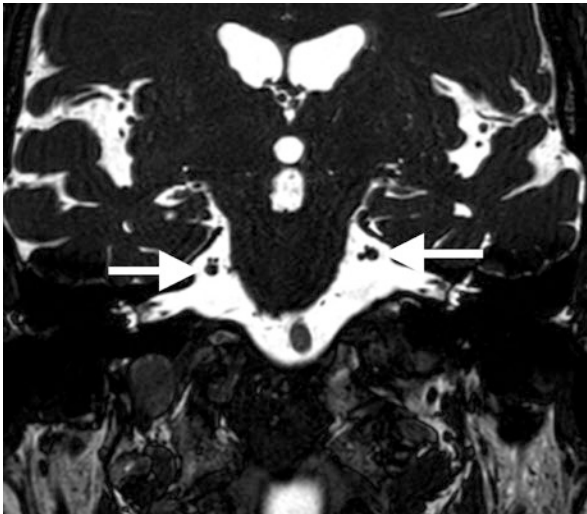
Coronal T2-weighted SSFP image depicts the cisternal segments of each trigeminal nerve (arrows). Both nerves are bordered by pairs of vessels (hypointense foci along the superior border of the right CN V and medial and superior-medial borders of the left CN V)
